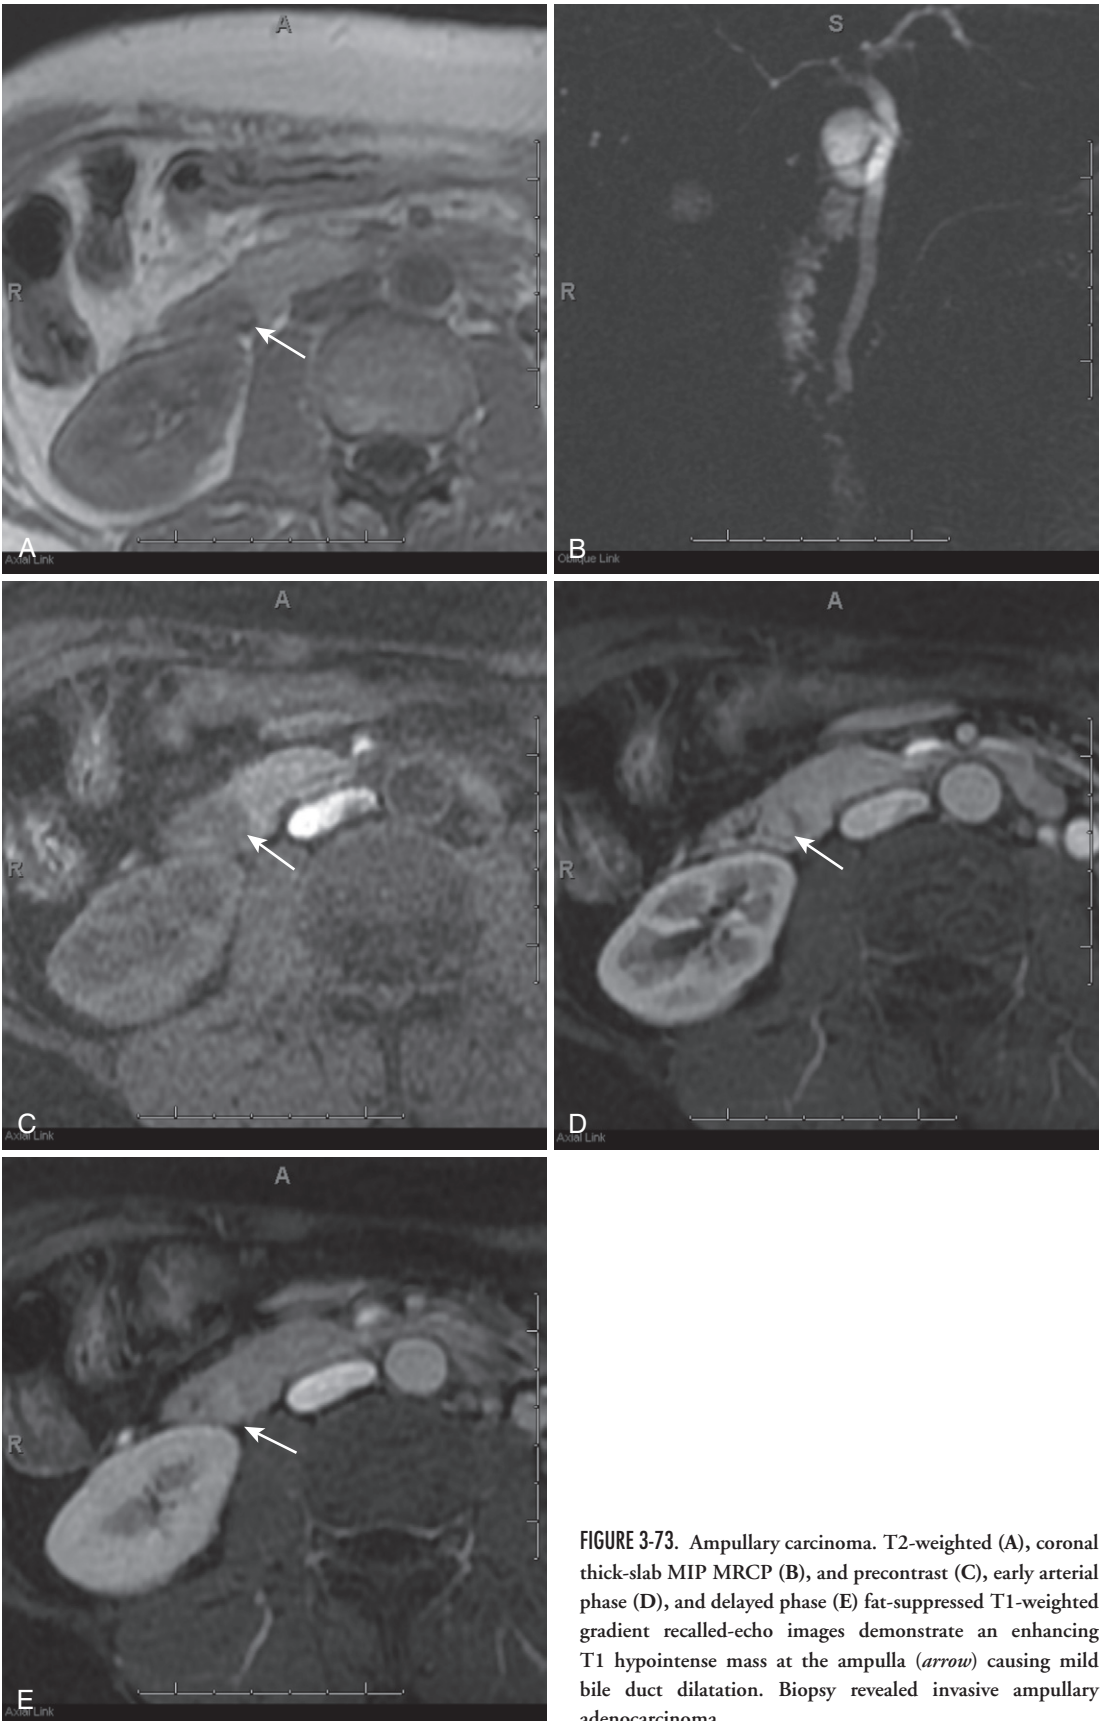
Ampullary carcinoma. T2-weighted (A), coronal thick-slab MIP MRCP (B), and precontrast (C), early arterial phase (D), and delayed phase (E) fat-suppressed T1-weighted gradient recalled-echo images demonstrate an enhancing T1 hypointense mass at the ampulla (*arrow*) causing mild bile duct dilatation. Biopsy revealed invasive ampullary adenocarcinoma.
